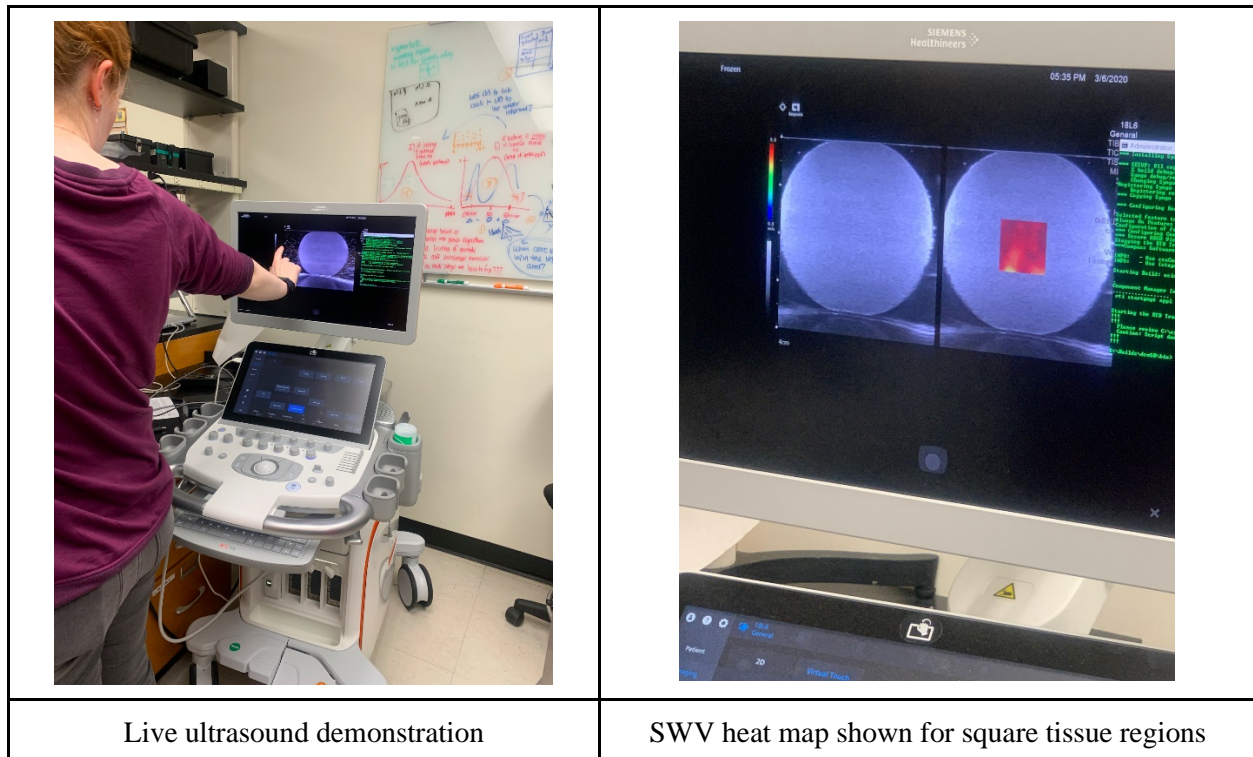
Photographs from live ultrasound demonstration
